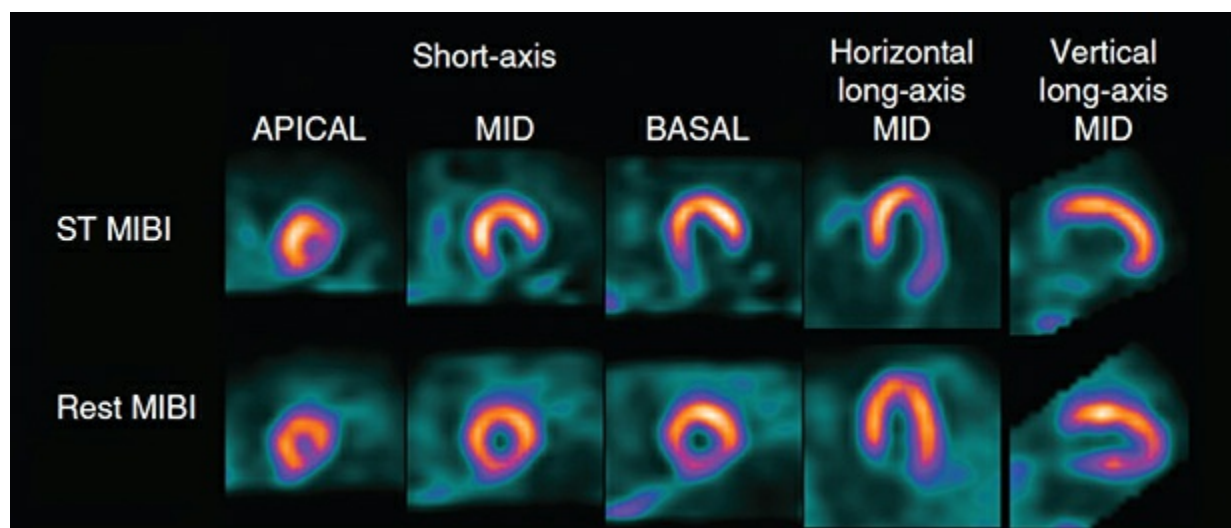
Adenosine stress/rest myocardial perfusion single-photon emission computed tomography images. Rest sestamibi (MIBI) demonstrated minimal (borderline) perfusion defect in the inferior wall. Stress imaging revealed evidence of severe and extensive ischemia in the inferior and inferolateral wall (41% of the left ventricle).
